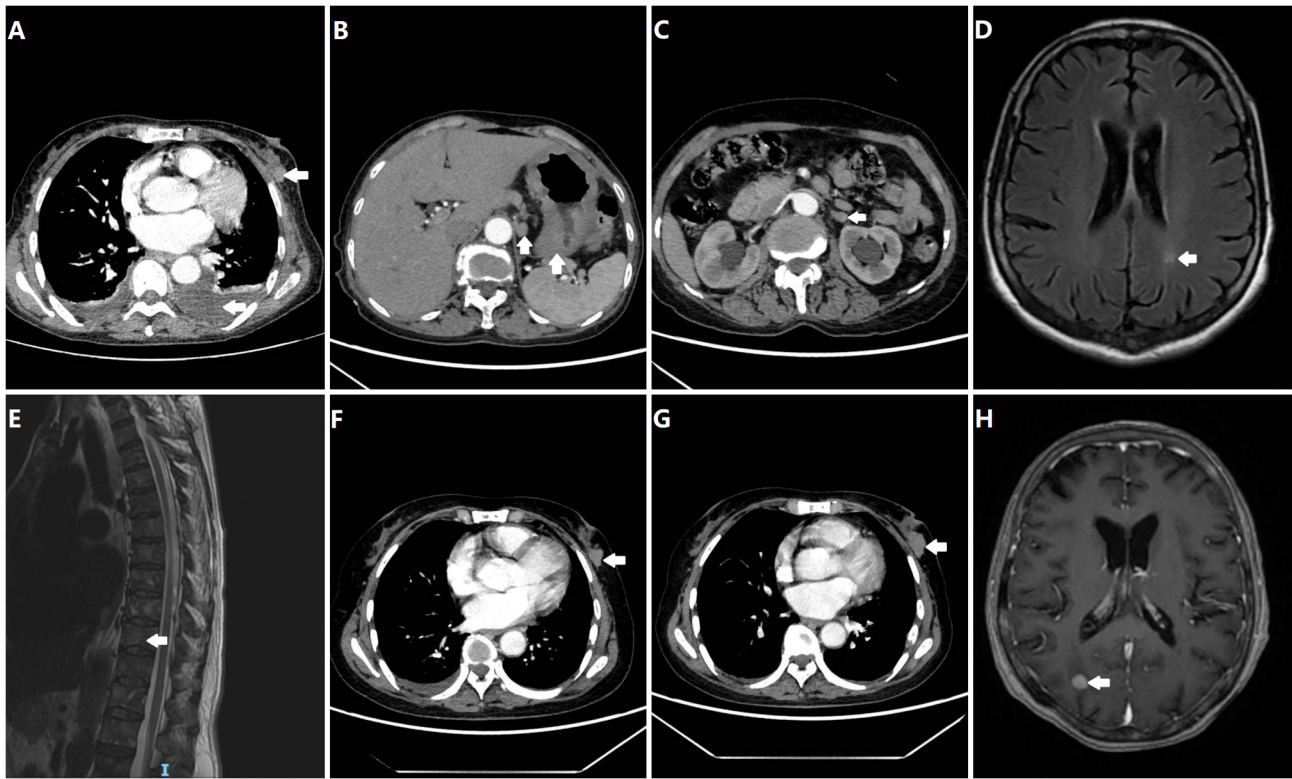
(A) Chest CT demonstrating a left breast mass (arrow) with localized skin thickening and left pleural effusion. (B) The gastric wall was thickened with enlarged perigastric lymph nodes. (C) Metastatic nodules of the adrenal gland. (D) Cerebral metastases in the left occipital lobes. (E) Multiple metastases in the spine and vertebral body attachments. (F) Stable disease of breast cancer after two cycles of first-line chemotherapy. (G) Disease progression of breast cancer. (H) New intracranial metastases on the right side of the brain. White arrows indicate tumor location in all images.
